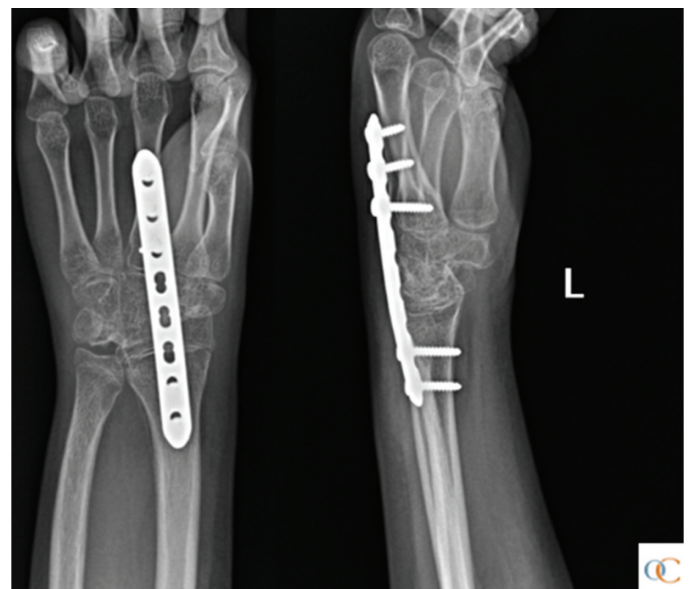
Longer-Term Follow-Up Radiographs: AP and lateral wrist radiographs obtained at longer-term follow-up visit. Bridging trabeculae from the radial epiphysis to the midcarpal bones indicates a successful wrist fusion.
